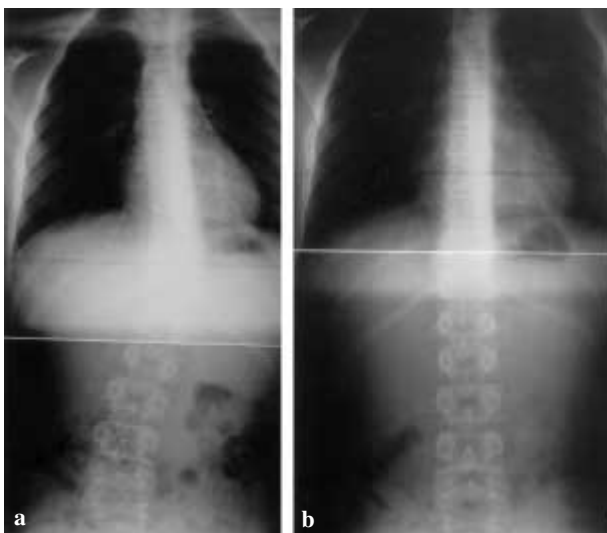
a. Anteroposterior radiograph of the spine in Case 4 showing scoliosis.
